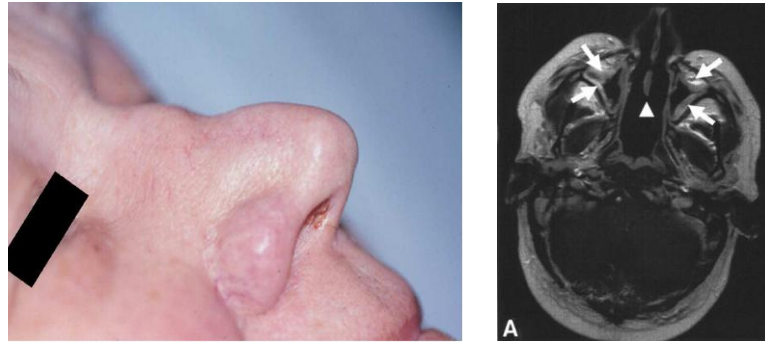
Saddle-nose deformity of GPA patient: left picture of an example of saddle-nose deformity in a patient with GPA [3]; right magnetic resonance imaging (MRI) of an example of saddle-nose deformity in a patient with GPA. The loss of nasal conchae and destruction of the nasal septum is indicated by triangle; the inflammatory tissue around is indicated by arrows [10].
